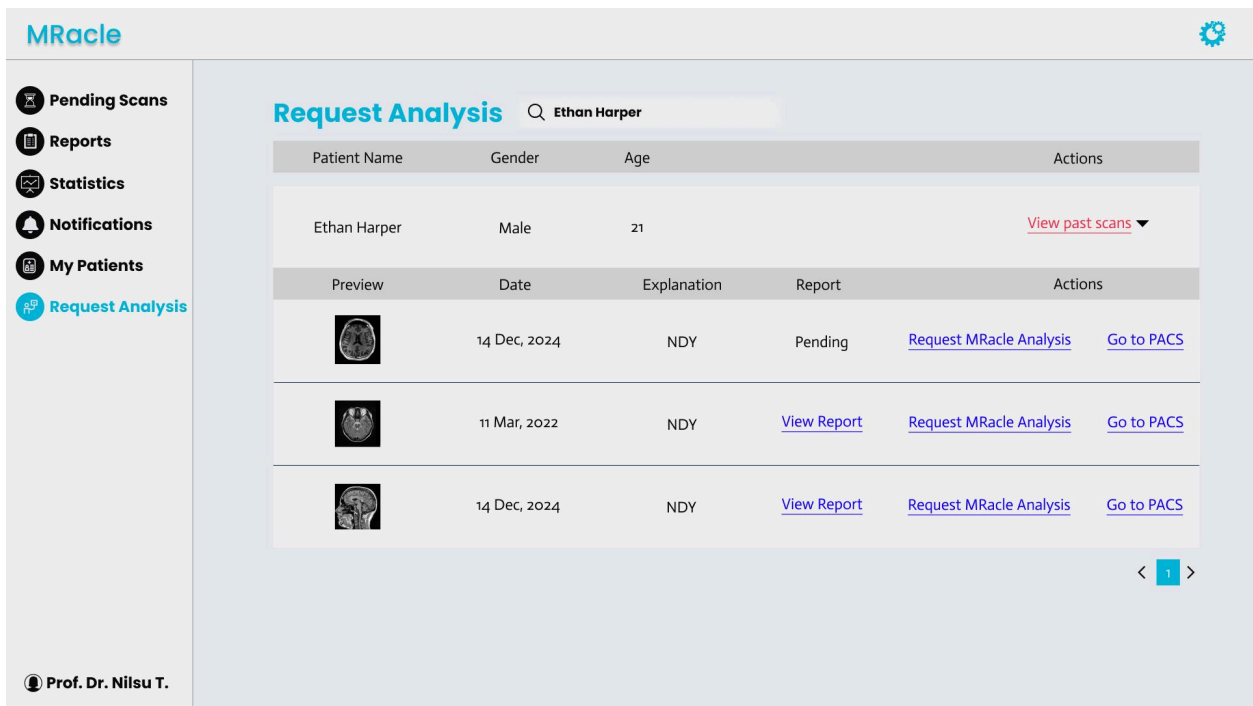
Screen of Radiologists Request MRacle Analysis for Patients' Old MRI Scans
